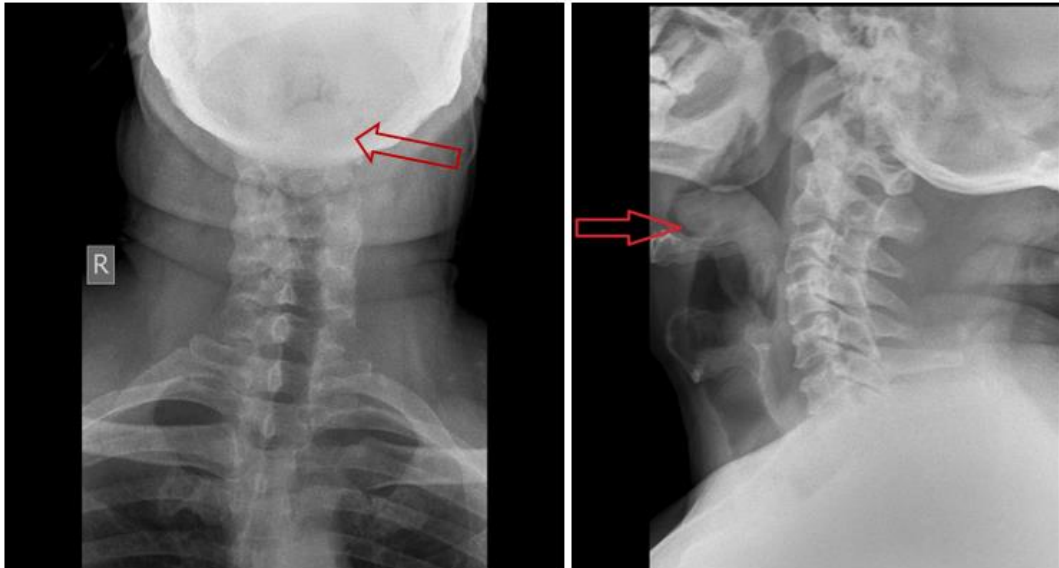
Plain radiograph neck AP & lateral views showing a well-defined soft tissue opacity in the left supraglottic region just above the level of hyoid bone and extending posteriorly upto the posterior wall of hypopharynx and closely abutting it
